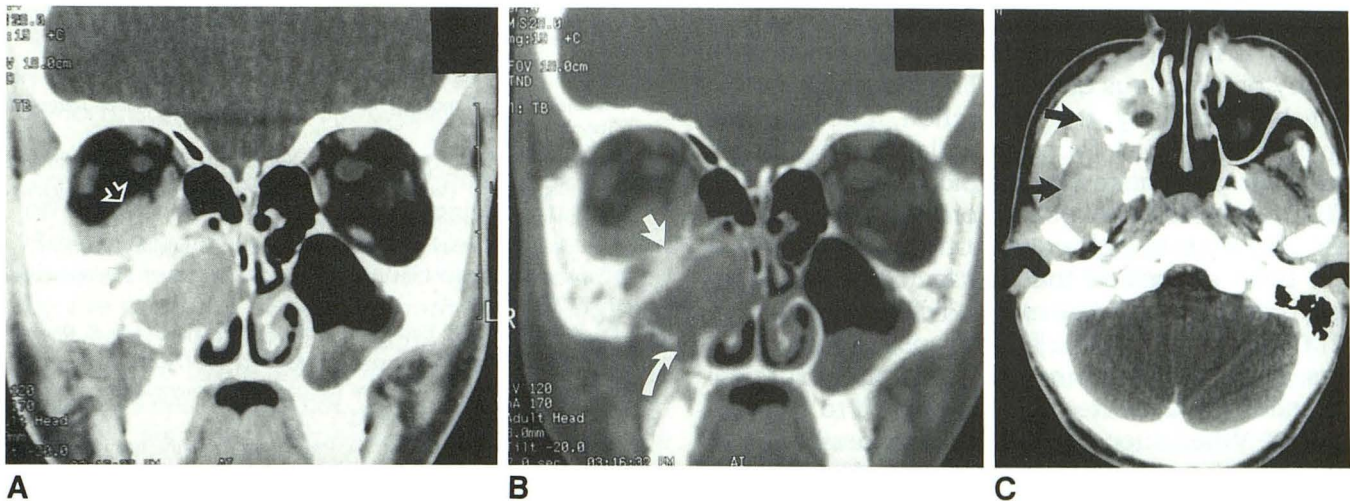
A, Coronal narrow soft-tissue window; B, Wide bone window; C, Axial soft-tissue window. CT scans show a soft-tissue mass in the right maxillary sinus and right nasal fossa. The mass infiltrates the right infratemporal fossa (*black arrows*) obliterating the normal fat planes (compare with normal left side). The antral tumor extends into the right orbit (*open arrow*), and there are regions of bone destruction (*curved arrow*) and thickened and sclerotic bone (*solid white arrow*). There are incidental inflammatory changes in the left maxillary sinus.
